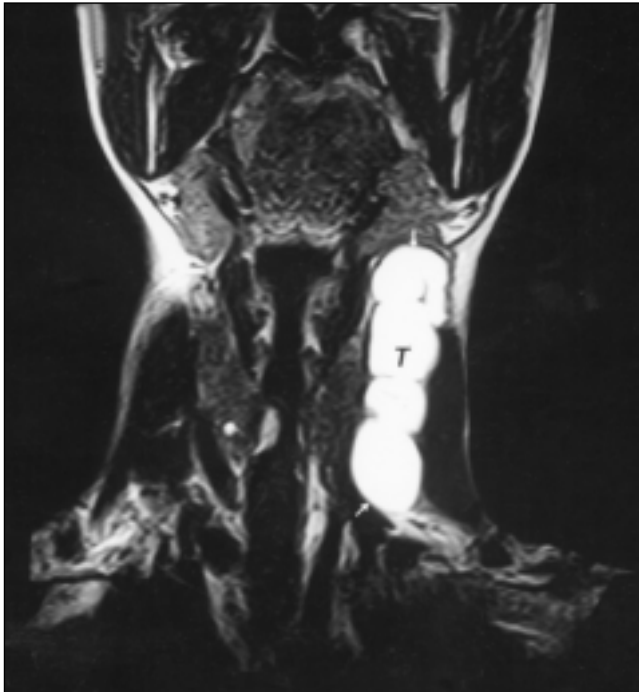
Coronal MRI scan shows a cystic mass in the left neck.
